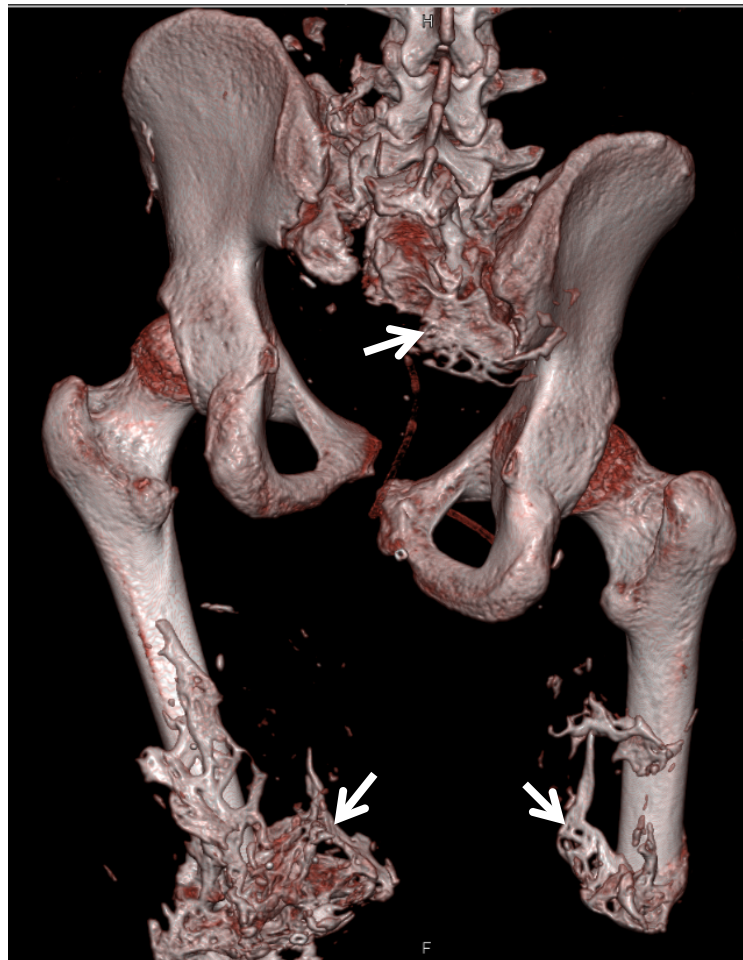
3D computed tomographic reconstruction of the pelvis and residual femora of a combat-injured patient. White arrows = heterotopic ossification.
